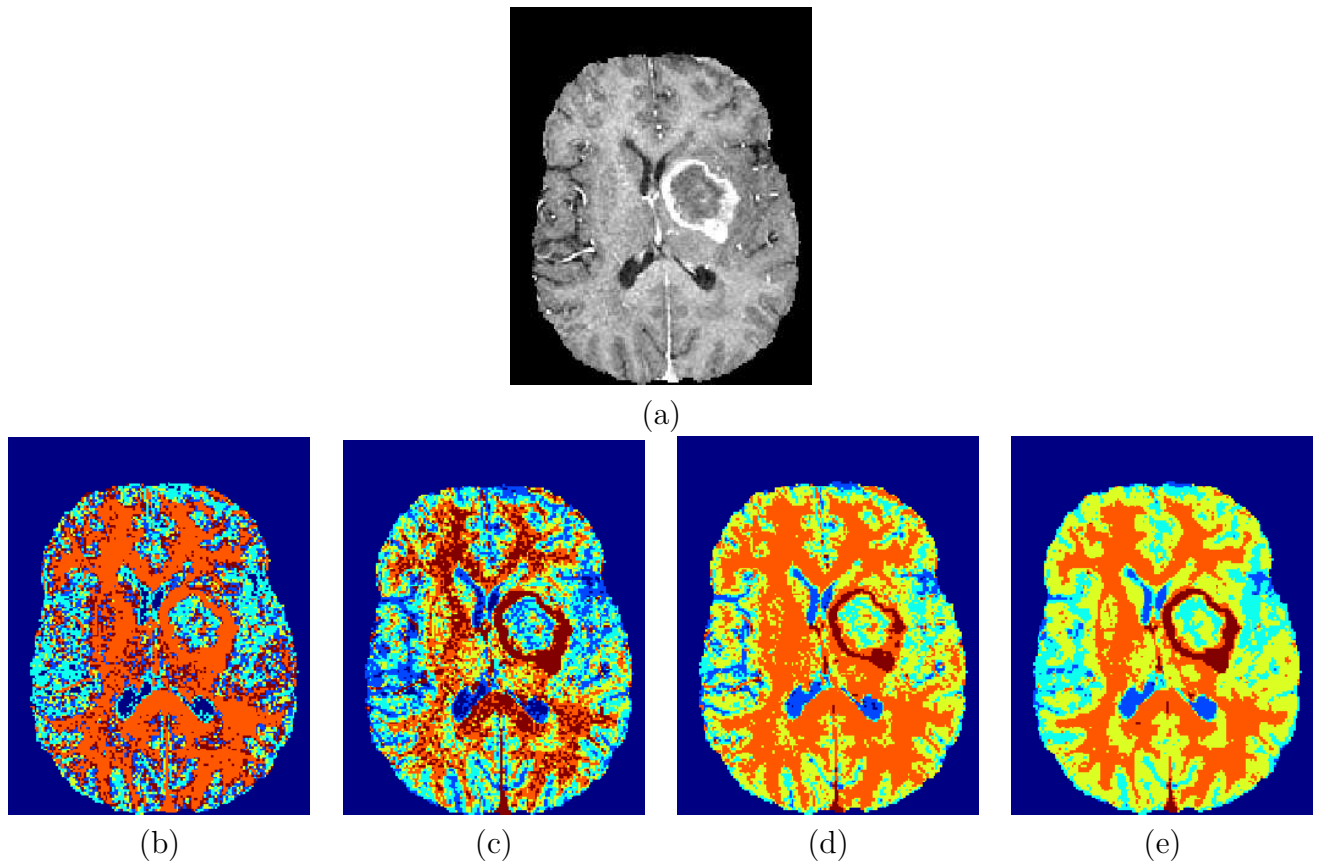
Comparison of classification results (6 classes) obtained by FCM, FPCM, MFCM and MPFCM for a ring-enhanced tumor. (a) One axial slice of the original contrast enhanced T1-weighted image. (b) Result of FCM classification. (c) Result of FPCM. (d) Result of MFCM. (e) Result of MPFCM. Here  $a = 5$ ,  $b = 3$ ,  $\beta = 0.2$  and  $n_w = 27$  for the MPFCM algorithm.
